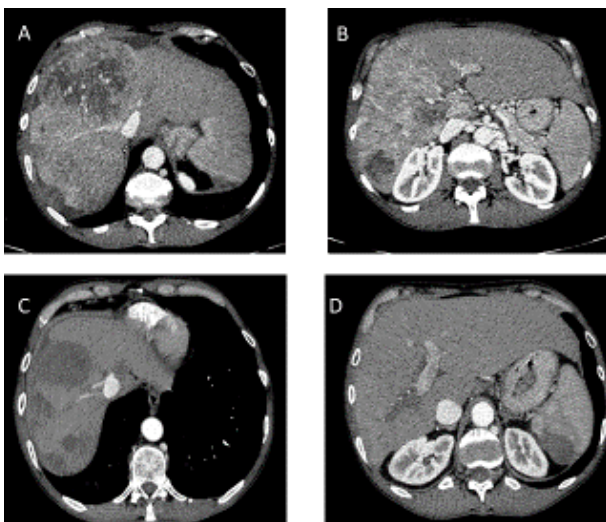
CT showing the spontaneous regression of HCC after COVID-19 infection (patient #1). A) HCC in the transition of segments VIII e IV. B) Tumoral thrombe inside the portal vein right branch. C) Regression of enhancement and reduction of the size of the tumor. D) Reduction of diameter of portal vein right branch and lack of enhancement of tumoral thrombe.
